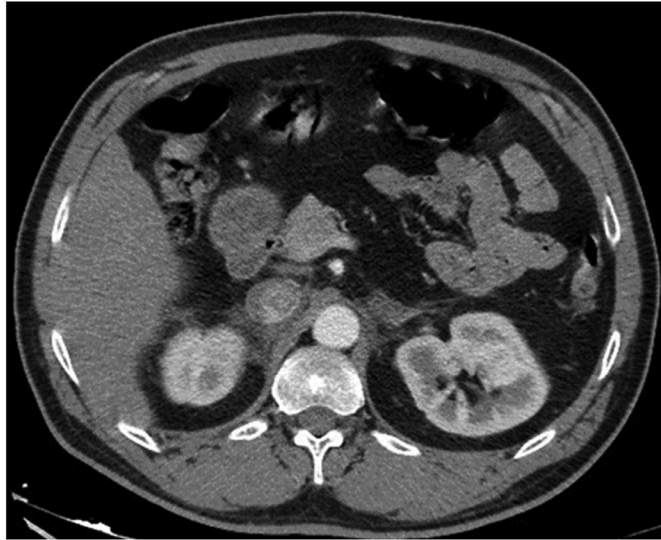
Postcontrast CT scan transverse view showing minimal bilateral residual lesions in the adrenal gland at the admission at hospital.
